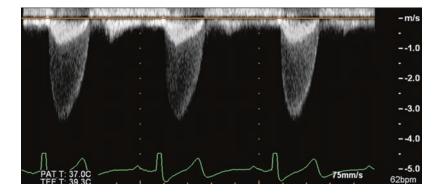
Descending aorta reversal of flow: (a) A longaxis view of the descending aorta is obtained, and a pulsed-wave Doppler beam is placed within the aorta. The waveform demonstrates normal systolic forward flow (*green arrow*); however, holodiastolic flow reversal (*red arrow*) is noted, which is indicative of severe aortic regurgitation. (b) A suprasternal notch aortic arch view (TTE) with the pulsed-wave Doppler sample volume 1 cm distal to the left subclavian artery takeoff, showing holodiastolic flow reversal (*green arrow*). (c) A subcostal descending aorta long-axis view (TTE) with pulsed-wave Doppler showing diastolic flow reversal (*green arrow*)
